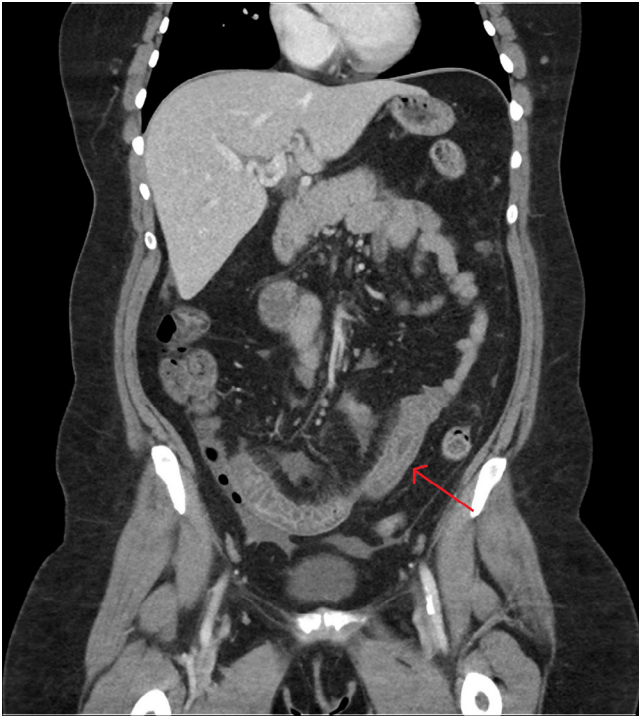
Long segment of submucosal edema, vasa recta engorgement, and a small amount of mesenteric-free fluid marked by the arrow on coronal computed tomography scan of the abdomen. Findings persisted in multiple studies over a 2-year period while taking angiotensin-converting enzyme inhibitors.
